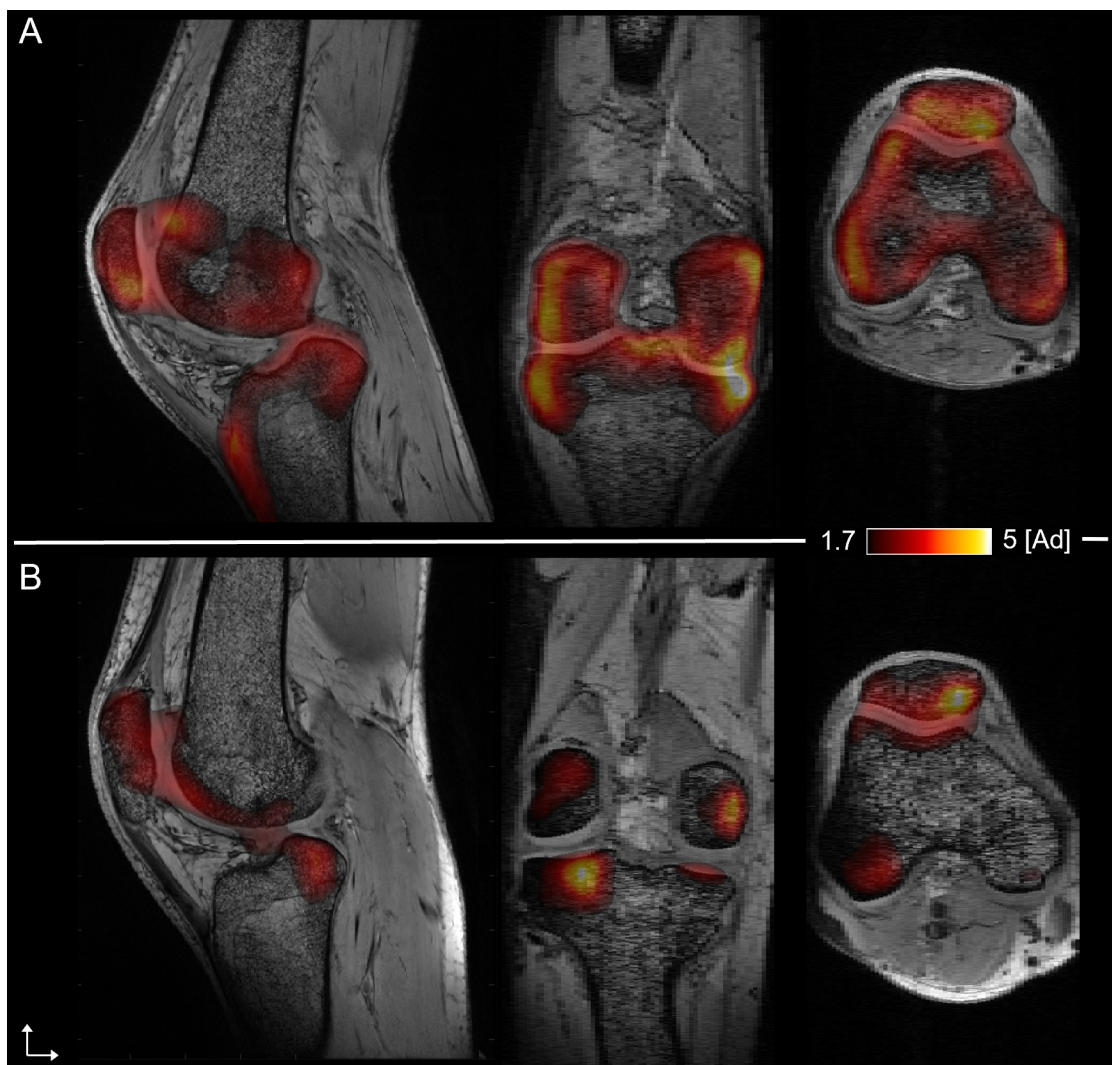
Merged PET-UHF MRI. Sagittal, coronal, and axial plane of merged PET-UHF MRI of the knee articulation of the patient before (A) and after (B) treatment by TNF-antibodies. “[Ad]” refers to a dimensional. Values higher or equal to 2.5 are considered indicative of “hypermetabolic” activity.
